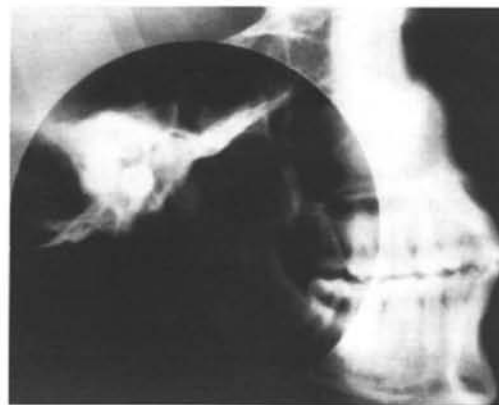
Lateral cephalometric radiograph of a skull taken with the TMJ Orthoceph Slimline Cassette System (Denar Corp., Anaheim, CA, USA). This system uses intensifying screens of different speeds to produce images with greater subjective clarity in the TMJ region
